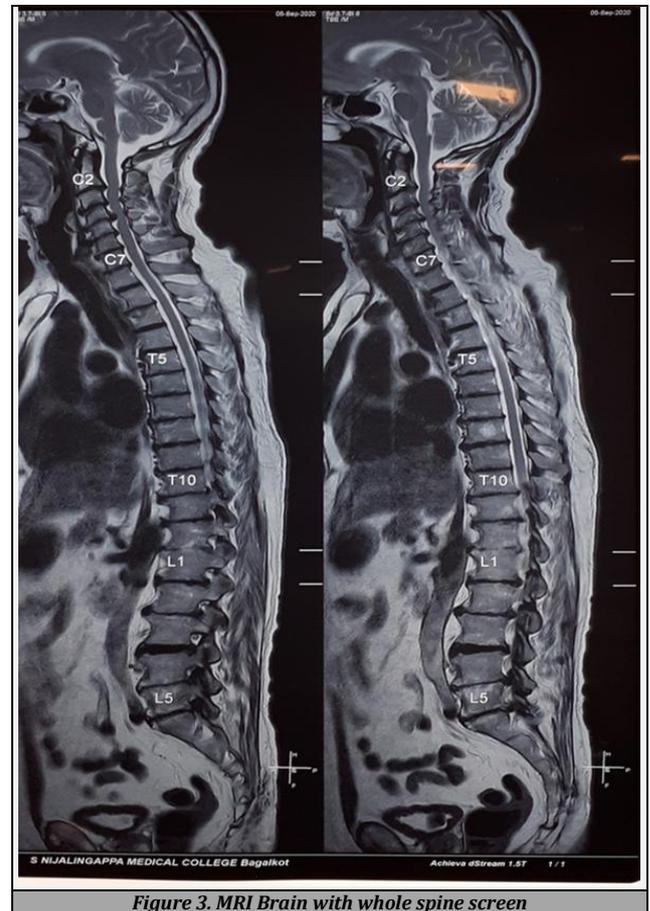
MRI Brain with whole spine screen
